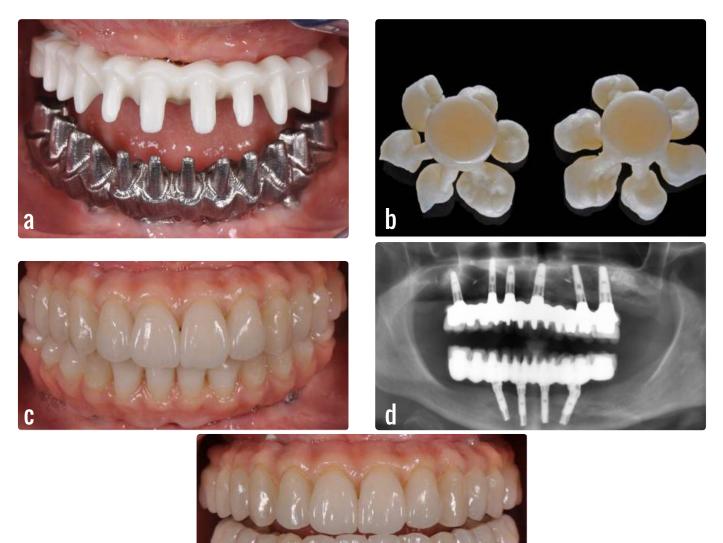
Photos of a) frameworks in situ during try-in, b) full-contour lithium disilicate crowns obtained using press technology, c) final rehabilitation after the extra-oral cementation of the crowns on the abutments, d) X-ray evaluation after 5 years of function. Note that in the mandible, the presence of a 2-unit distal cantilever prevented the use of zirconia as a framework material, e) complete-arch rehabilitation after 5-years of function.
